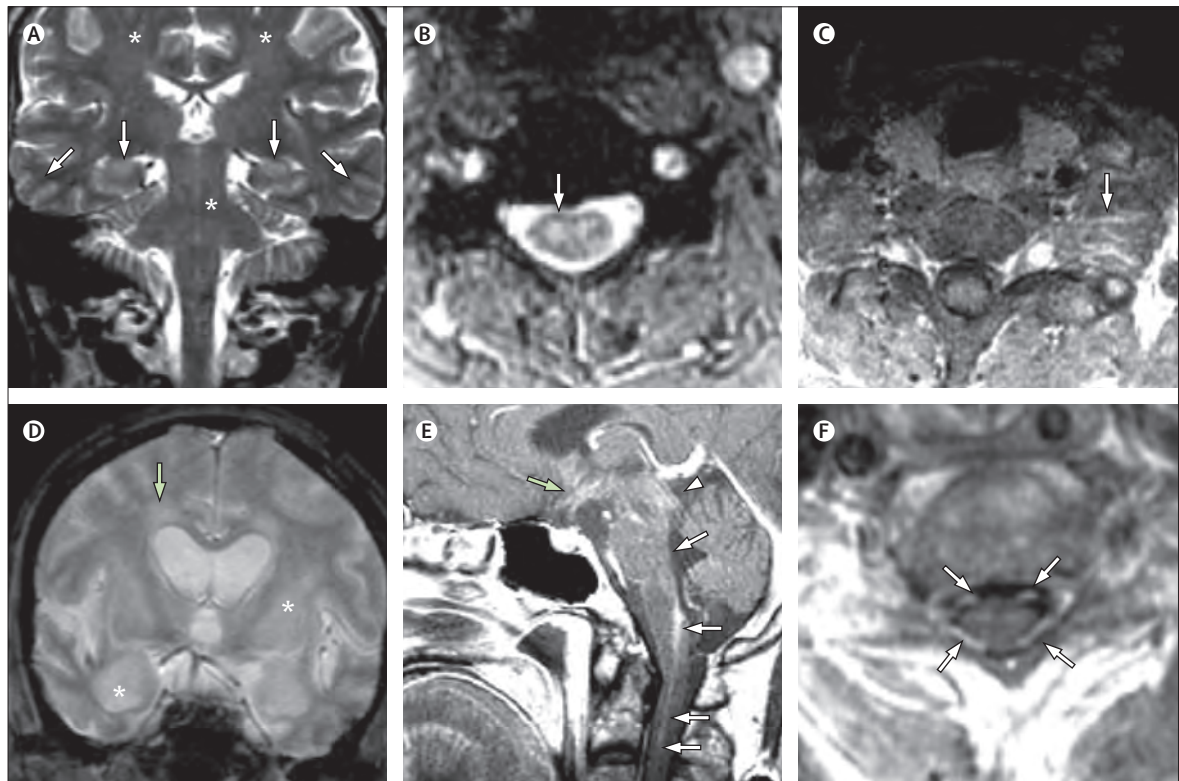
MRI in patients with rabies
